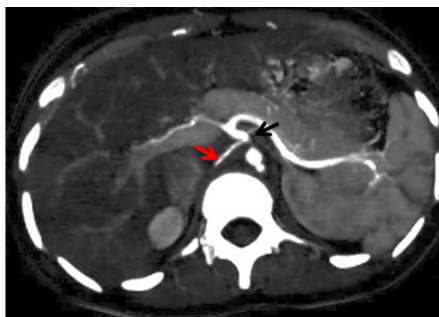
Axial MIP image show Replaced RHA (Red arrow) originating from CT (Black arrow).
